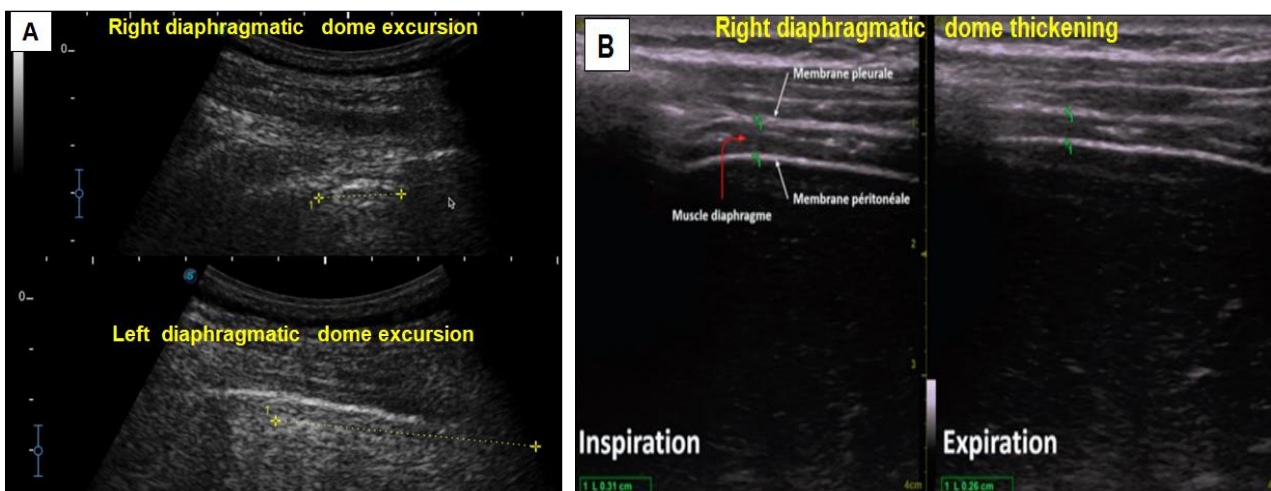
Diaphragmatic ultrasound images showing a diaphragmatic excursion of less than 10mm on the right (A) and a 19% thickening fraction (B) (thickening fraction= (inspiration thickness- expiration thickness)/ (inspiration thickness- expiration thickness) x 100) both parameters indicate right diaphragmatic paralysis.
